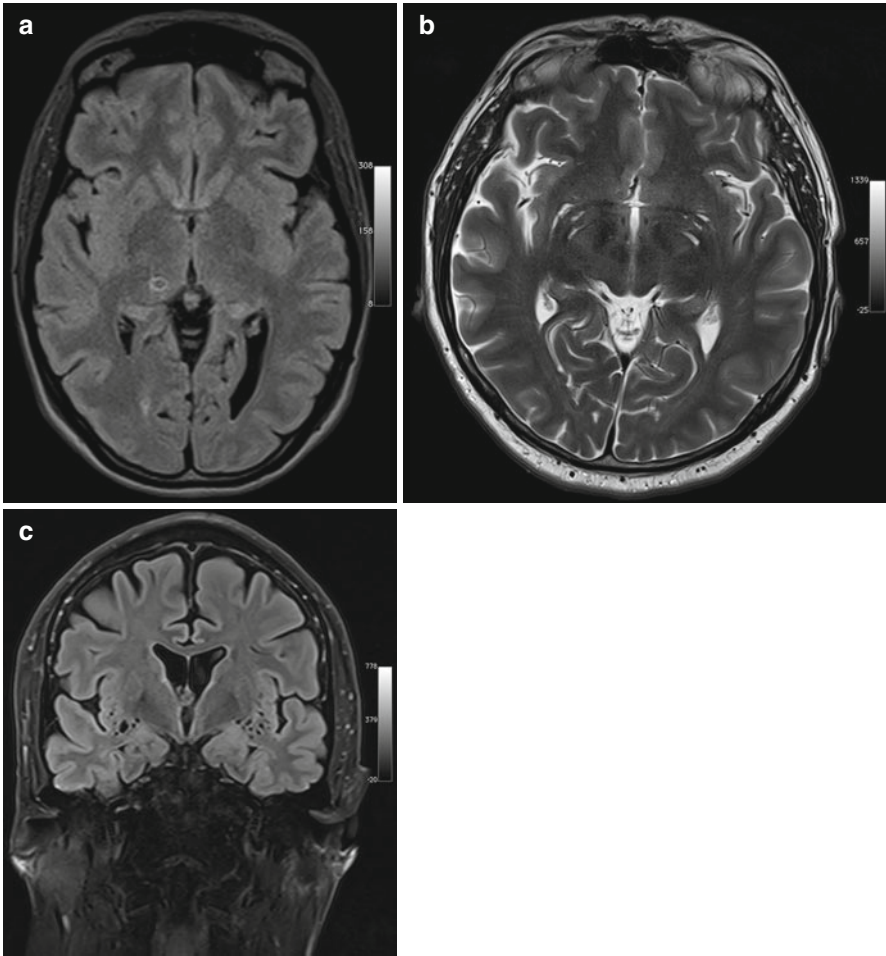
Incidental screening findings and workup in two subjects. (a) A 42-year-old male subject with a smoothly marginated lesion isointense to CSF in the thalamus on the right and slightly increased signal intensity of surrounding brain on axial T2w FLAIR image. This appearance suggests an enlarged perivascular space. (b, c) In a second case, a 23-year-old man, enlarged perivascular spaces are demonstrated by MRI workup performed at 3 T. There is enlargement of the perivascular spaces in the basal ganglia on axial T2w TSE image (b) and in the insular region bilaterally on coronal T2w FLAIR image (c)
